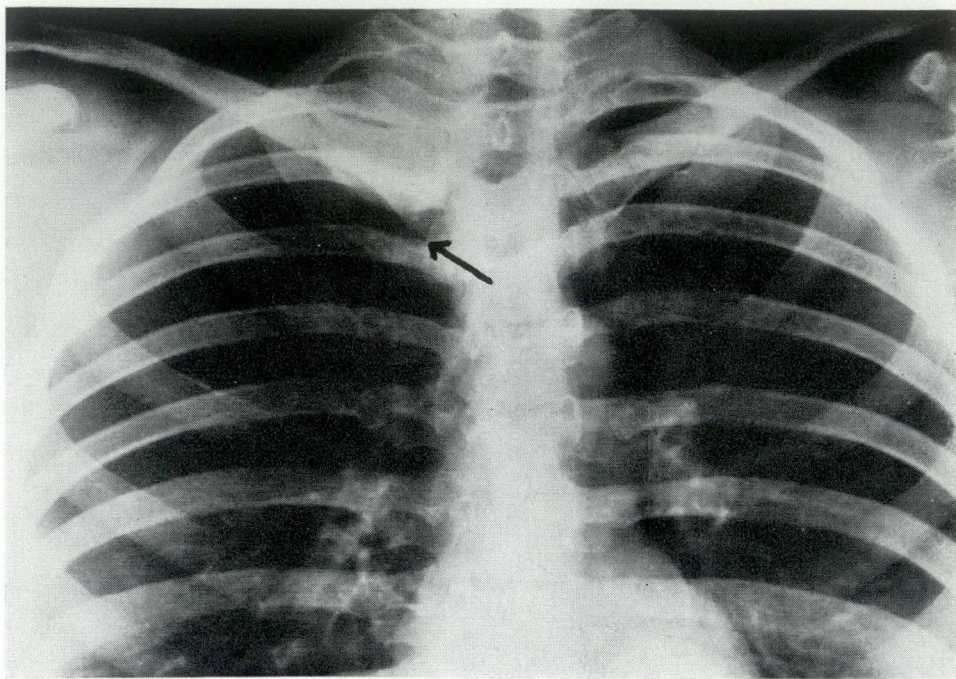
Mrs. L.B. Chest radiograph showing a round shadow in right thoracic inlet; antero-posterior view.
